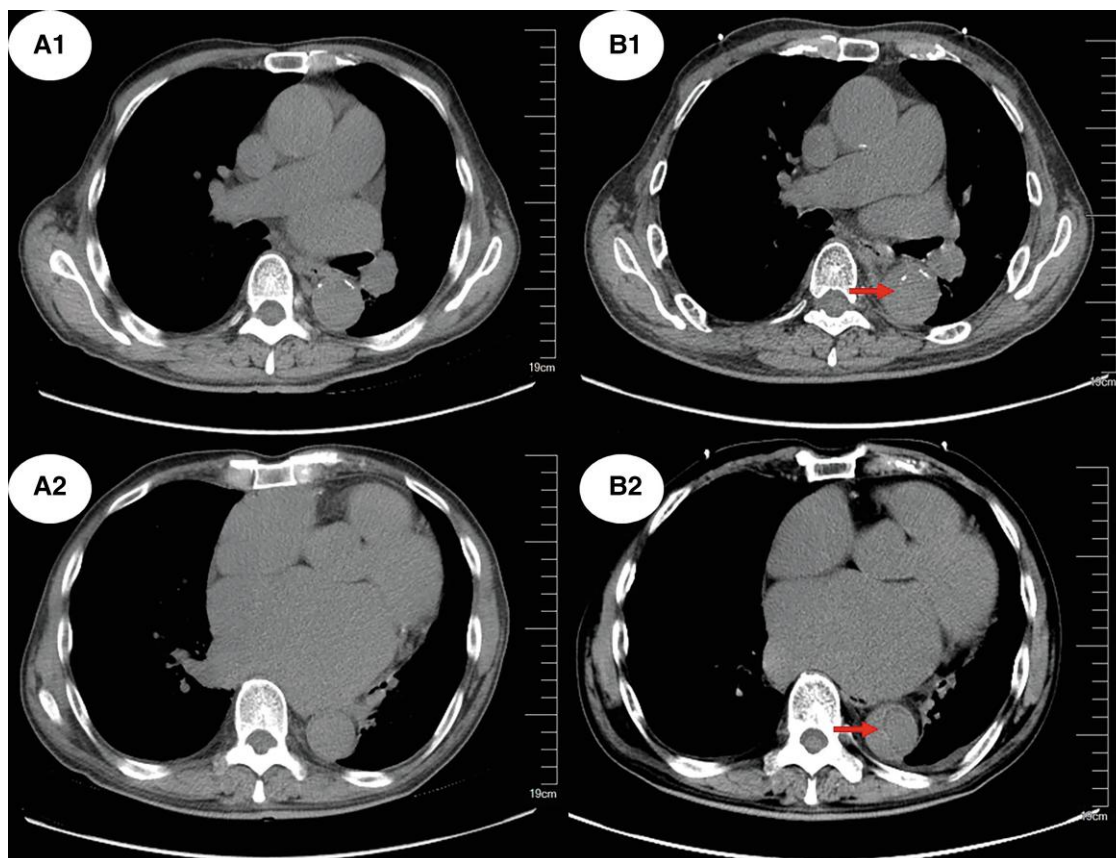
Computed tomography scan revealed a suspected aortic dissection (B1 and B2), which was not found on pre-procedure computed tomography (A1 and A2).
